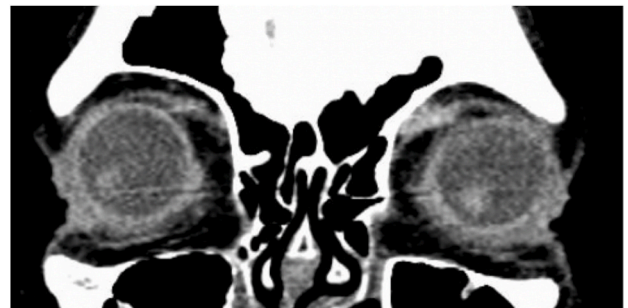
MRI at 6 months postoperatively. The MRI demonstrates inflammatory material surrounding the trochlea and superior oblique without progression.
